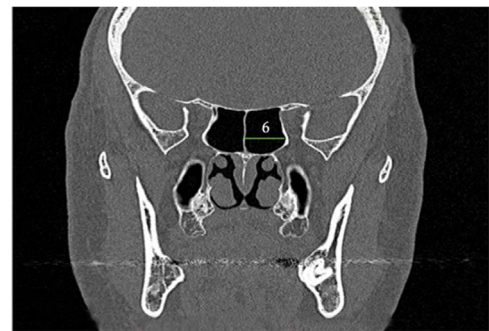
Coronal CT scan shows the left line 6 of the sphenoid sinus (6).
